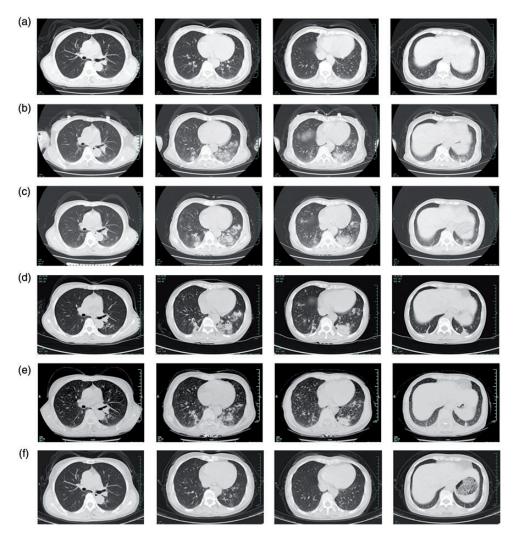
Timeline of the patient's lung computed tomography (CT) scan: (a) 8 April 2018, (b) 18 April 2018, (c) 27 April 2018, (d) 5 May 2018, (e) 24 May 2018, and (f) 5 December 2018.
